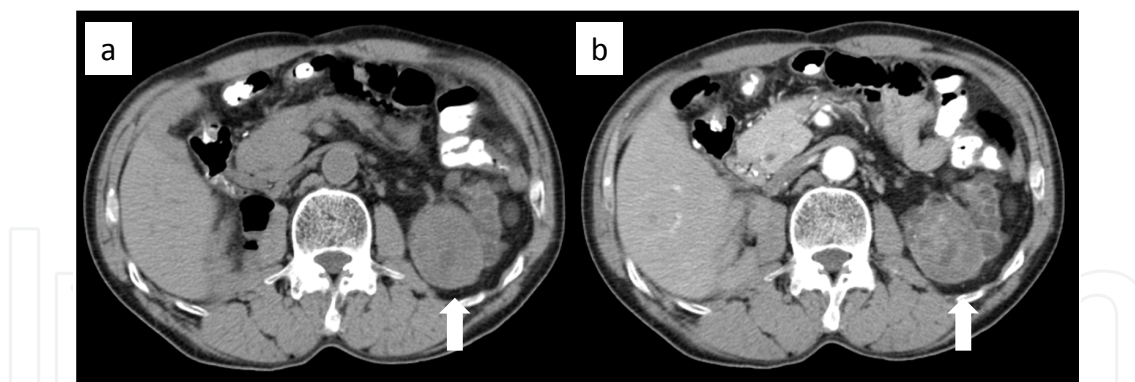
CT images of a 65-year-old man with ACD-associated RCC. a: Unenhancement CT shows multiple small cysts and a mass (arrow). b: At early enhancement phase, the mass (arrow) is slightly and heterogeneously enhanced.
